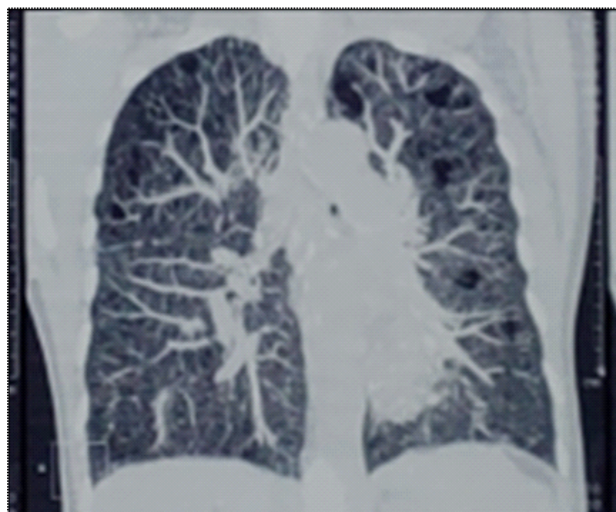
Coronal Section of HRCT Thorax Suggestive of bilateral cystic lung disease and features of fibrosis
